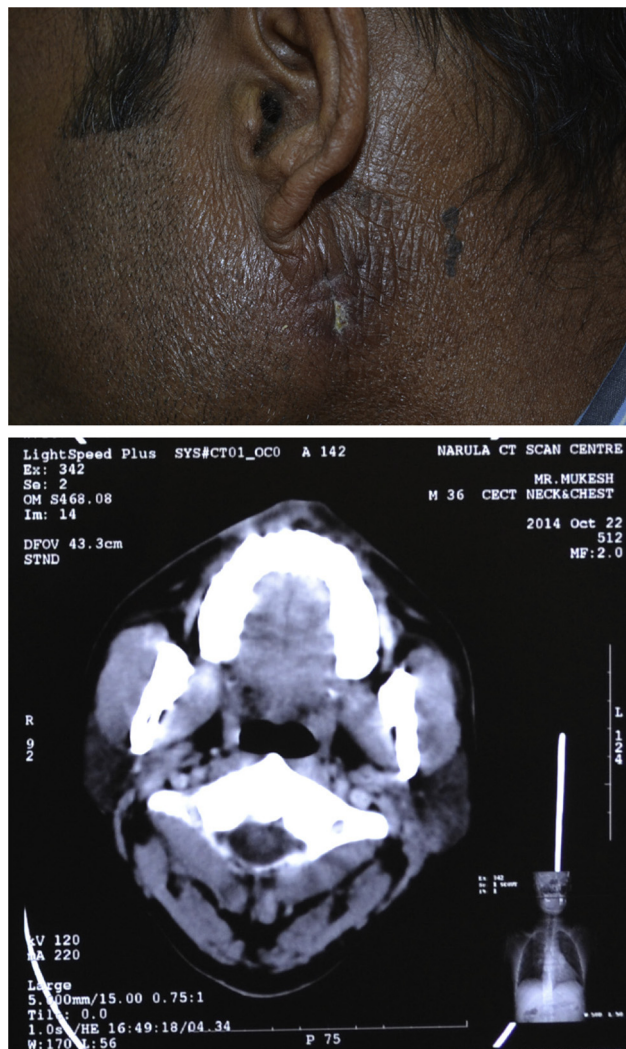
(a) Gross photograph showing parotid swelling in Patient-2. (b) CT scan of Patient-2 showing left Parotid swelling.
